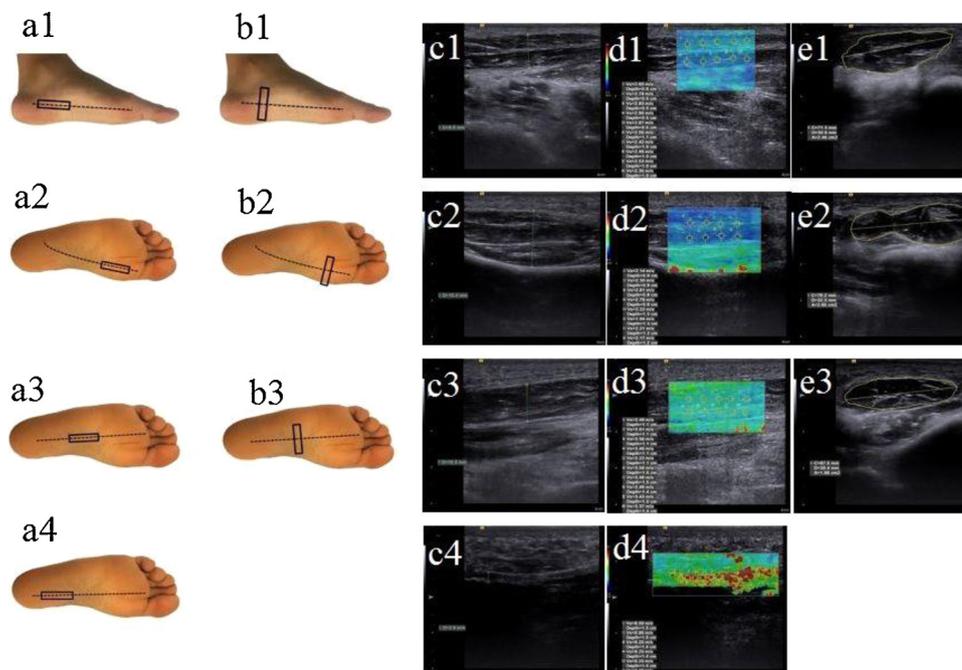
Probe location and ultrasound imaging measurements. (a) Probe position of the AbH (a1), FHB (a2), FDB (a3) and PF (a4) at thickness and stiffness measurements; (b) Probe position of the AbH (b1), FHB (b2) and FDB (b3) at cross-sectional area measurements; (c) 2-dimensional ultrasound image of the AbH (c1), FHB (c2), FDB (c3) and PF (c4) at thickness measurements; (d) Shear-wave elastography image of the AbH (d1), FHB (d2), FDB (d3) and PF (d4) at stiffness measurements; (e) 2-dimensional ultrasound image of AbH (e1), FHB (e2) and FDB (e3) at cross-sectional area measurements. Regions of interest were placed and corresponding shear wave velocity (m/sec) was recorded. Abductor hallucis, AbH; flexor hallucis brevis, FHB; flexor digitorum brevis, FDB; PF, plantar fascia.
